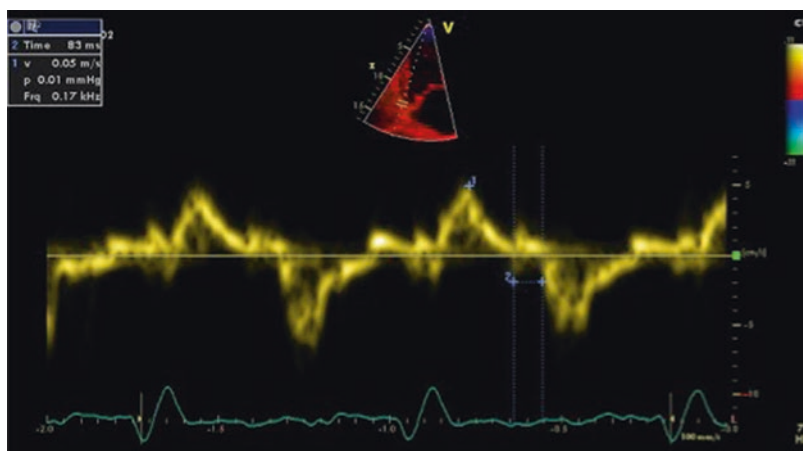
Transthoracic echocardiography, apical 4-chambers view, tissue Doppler imaging at the lateral tricuspid annulus: there is longitudinal RV dysfunction in a patient with PAH and severe RV global systolic dysfunction (S wave 5 cm/s)
